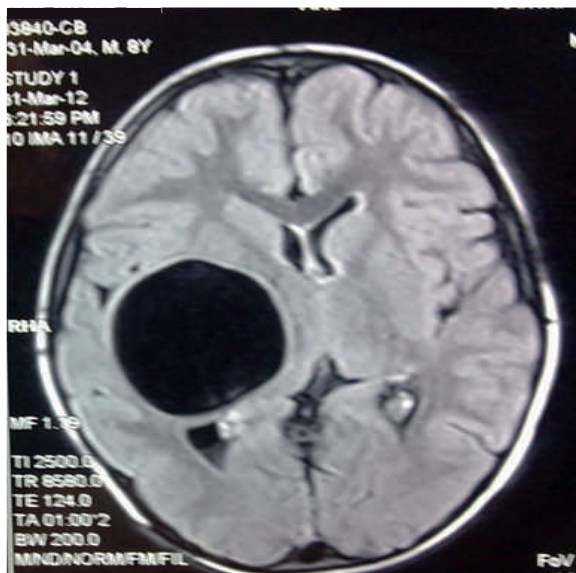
MRI T1 Showing Large Cystic Lesion In Right Temporoparietal Region
